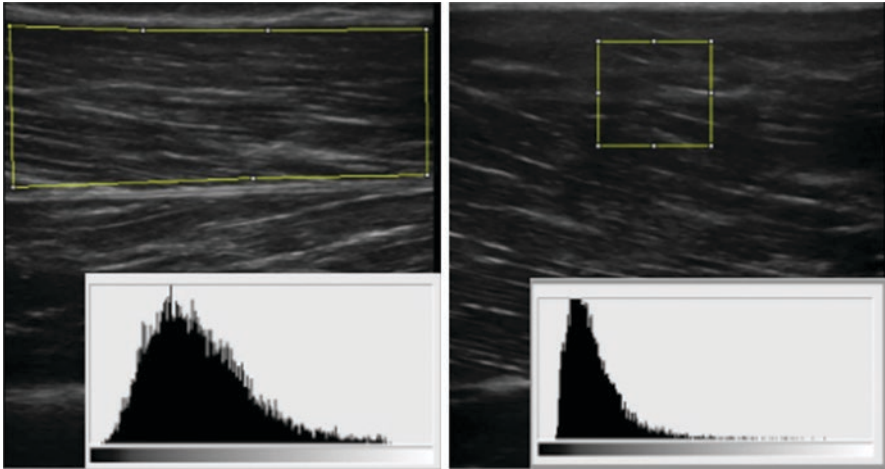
The muscle ultrasound echointensity. Ultrasound images of two different ROIs used to measure muscle echo-intensity. A maximum ROI was defined for each image to include as much of the muscle as possible, avoiding bone and surrounding fasciae (right panel). A smaller ROI was positioned approximately at the center of the muscle image (left panel)
